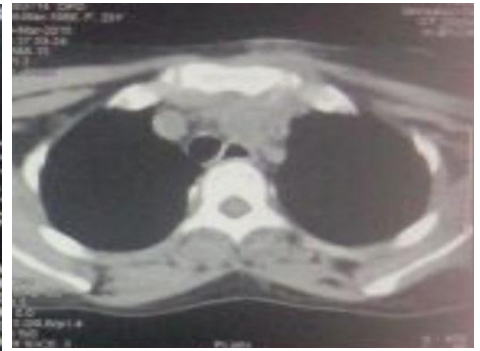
CT scan image showing collection at the left SCJ
